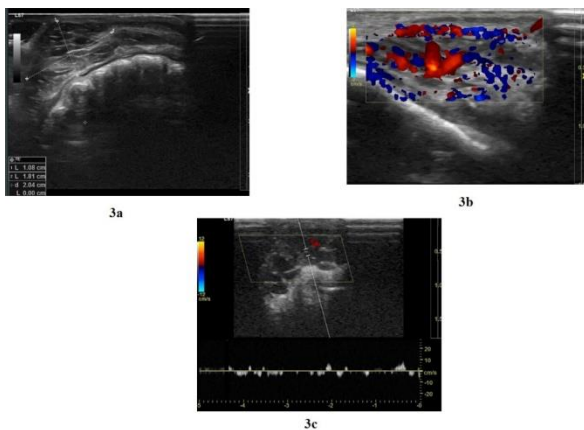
(a-c)- USG with color doppler
